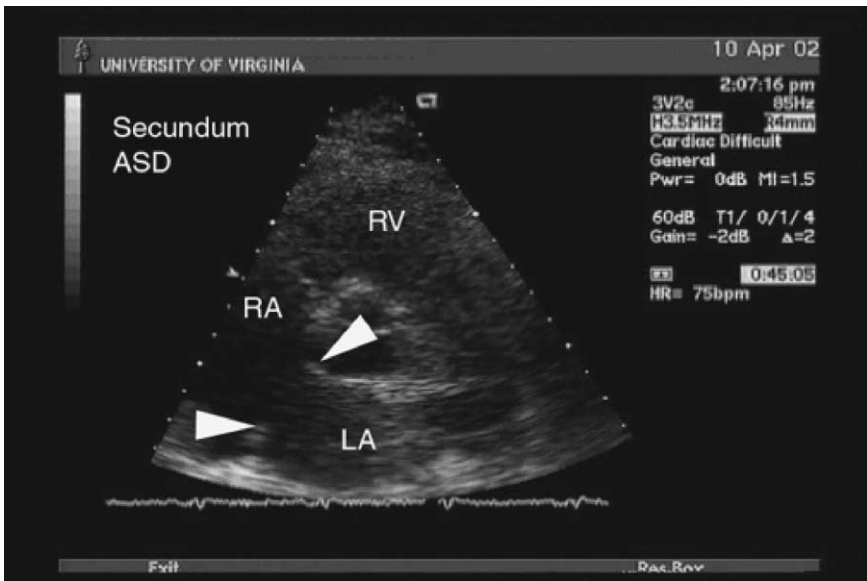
Two-dimensional parasternal echocardiogram of a patient with a large secundum ASD. The image shows a large defect in the interatrial septum, along with an enlarged right ventricle. Color Doppler imaging can also be used to demonstrate the direction of flow across the ASD. LA, left atrium; RA, right atrium.
